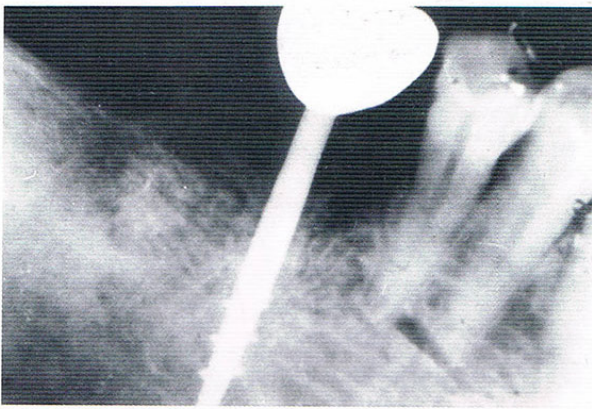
Radiograph taken 2 years after loading of implant
